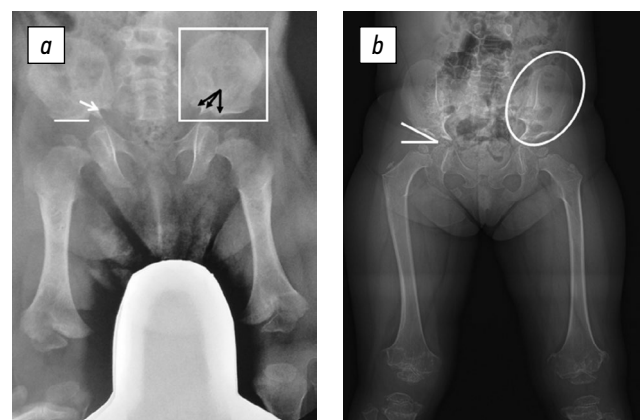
Radiographs of the hip joints and femoral bones in the frontal view of patients with achondroplasia (a) and pseudoachondroplasia (b): a, horizontal position of the acetabular hood (white line), narrowed sciatic notch (white arrow), ectrosyndactyly (black arrows), and square outlines of the iliac wings (white outline); b, skewness of the acetabular hood (white lines) and oval outlines of the iliac wings (white outline)
